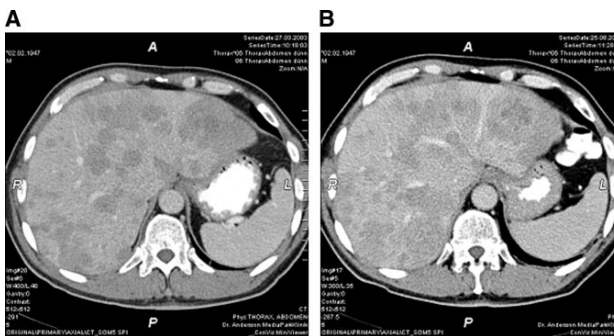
CT scans of patient 9. (A) Nine months after treatment with ^{90}Y -DOTATOC and 4 wk before treatment with ^{177}Lu -DOTATOC, CT scan shows multiple liver metastases. (B) Corresponding CT scan 4 mo after treatment with ^{177}Lu -DOTATOC shows minor response.
